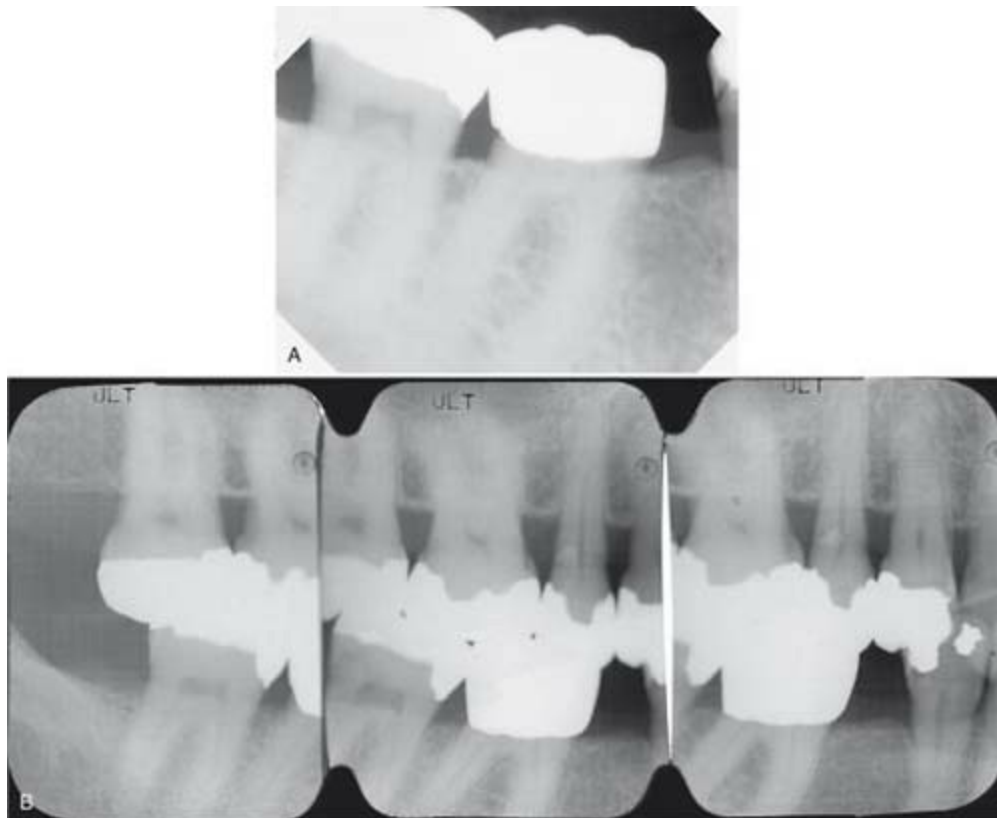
A, Distal open margin on tooth #30 (shown digitally). B, Distal open margin on tooth #30 not evident with plain-film radiography.
